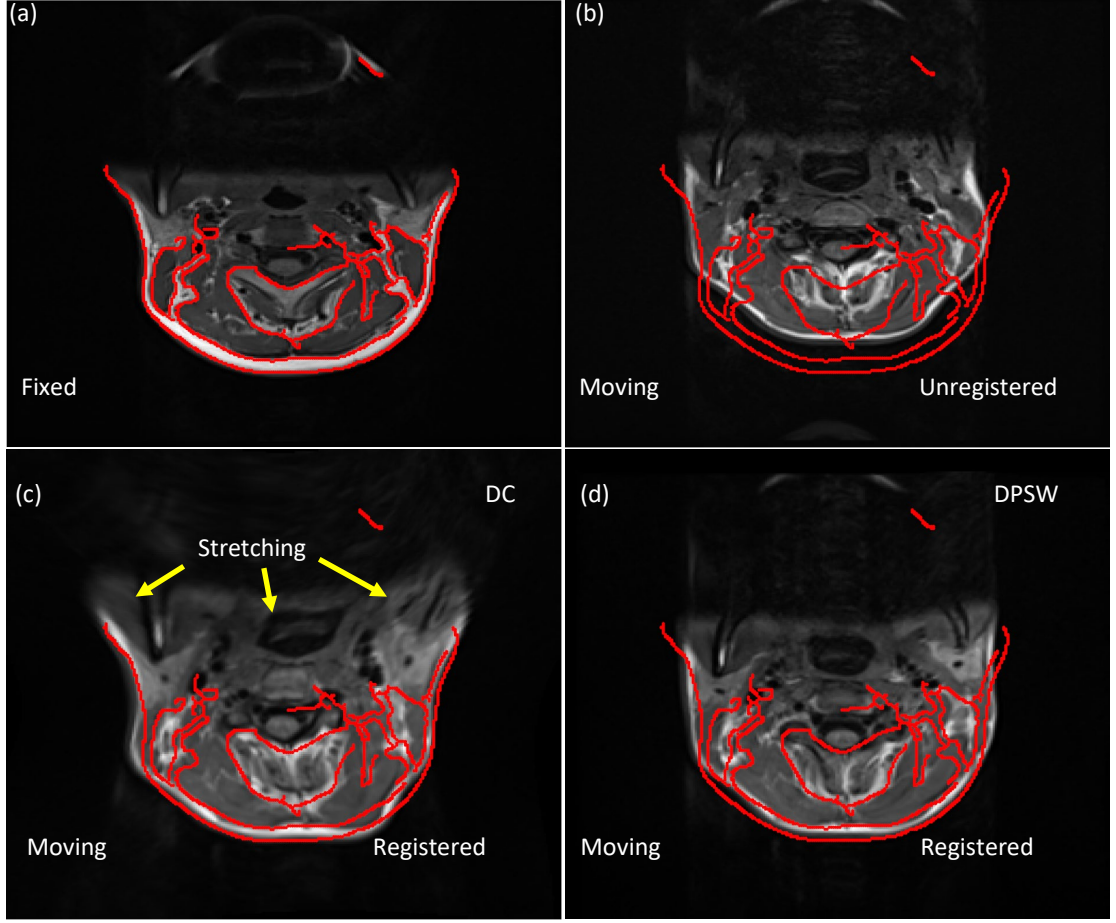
Registration results for two magnetic resonance imaging volumes using discrete cosine- and discrete periodic spline wavelet-based basis functions, showing a stretching effect in one slice of the former. The edges of the fixed image are superimposed in red over the unregistered and registered moving images. The registration is performed in 3D-3D, but the results are shown in 2D by taking one image from the 3D volume.
